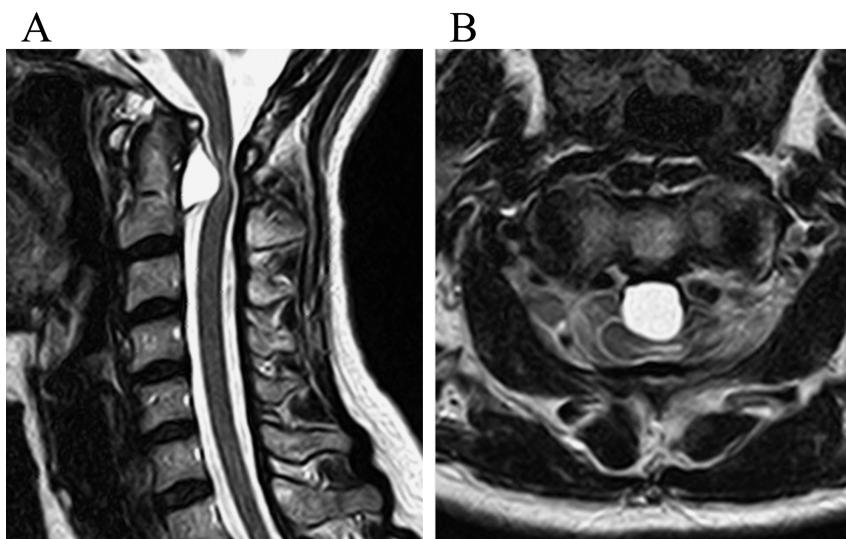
A and B, Sagittal and axial magnetic resonance images revealing a large cystic mass located posteriorly to the odontoid process of C2, which is severely compressing the spinal cord dorsally.
